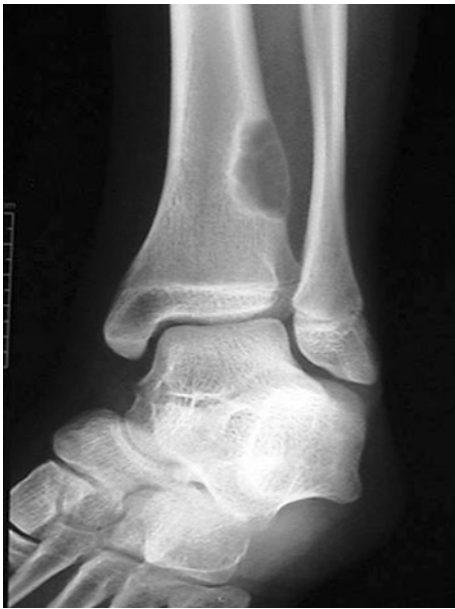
A 14.7-year-old boy presented with pain of his left ankle for more than 3 months. Plain radiographs demonstrated an eccentrically located and expansile radiolucent lesion in the metaphyseal of the distal end of the tibia. The cortex was thinned and the lesion had a prominent marginal sclerosis with a ground-glass appearance
